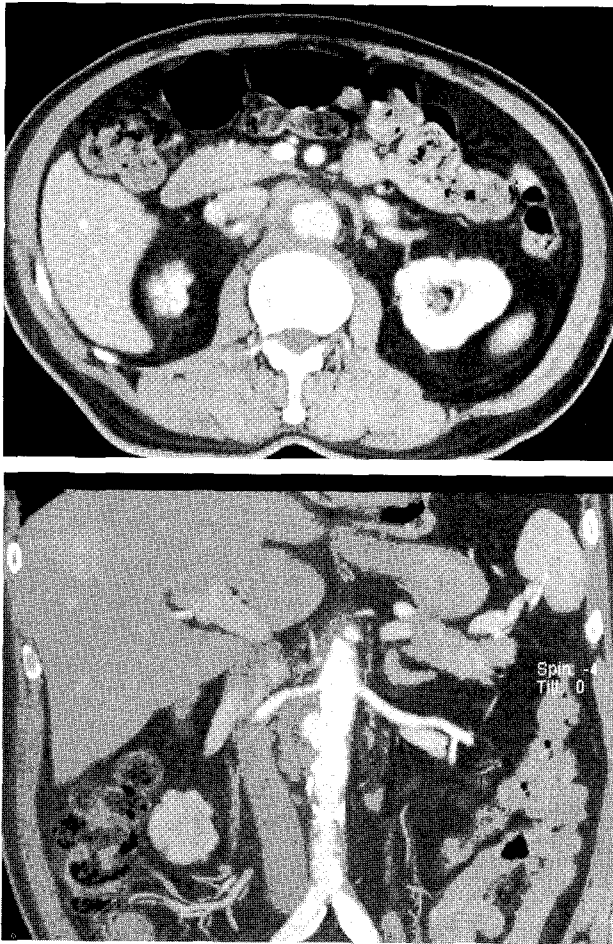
Repeat axial and coronal CT images at the same level, one month after antibiotics treatment, demonstrate increased size of aneurysm and no change of periaortic soft tissue density with enhancement.
